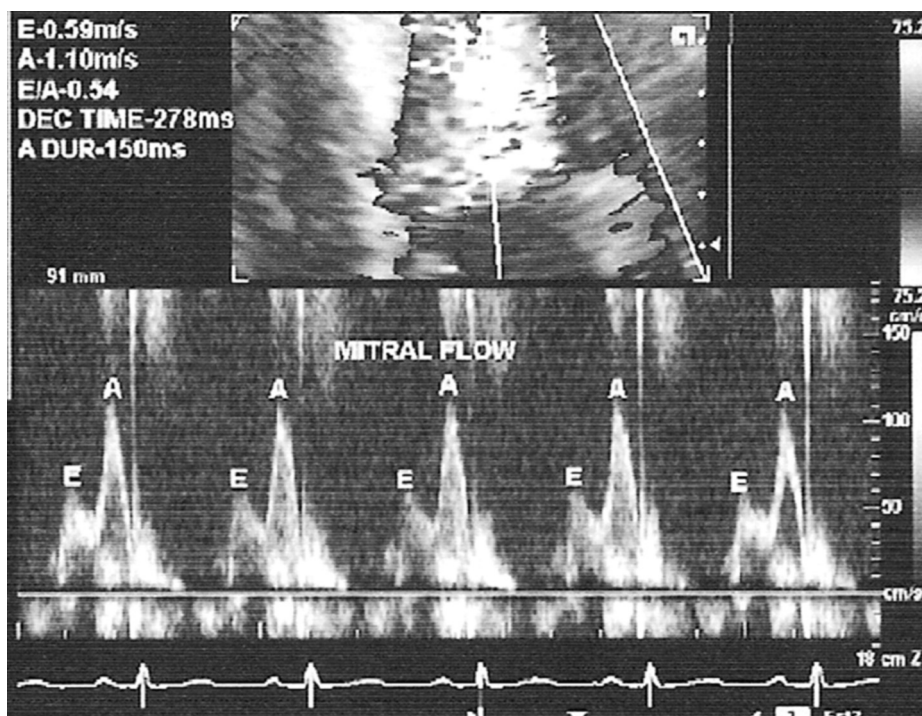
Pulsed Doppler evaluation of mitral flow. A – flow during atrial systole, E – flow during early diastole.
